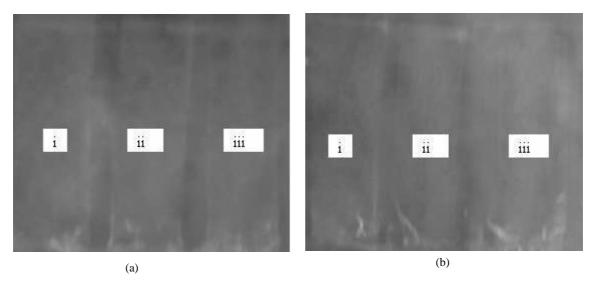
Neutron radiographic images: (a) S-layer collagen bandage immersed into serum for (i) 0.5 (ii) 1, and (iii) 2 minutes; (b) S-layer collagen bandage immersed into water for (i) 1, (ii) 2, and (iii) 4 seconds.
